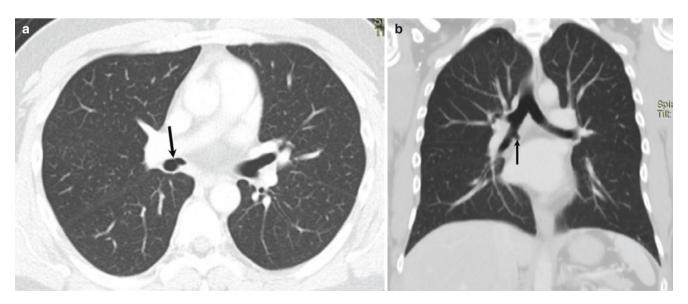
(a, b) Axial and coronal CT images showing a cardiac bronchus (arrow)
